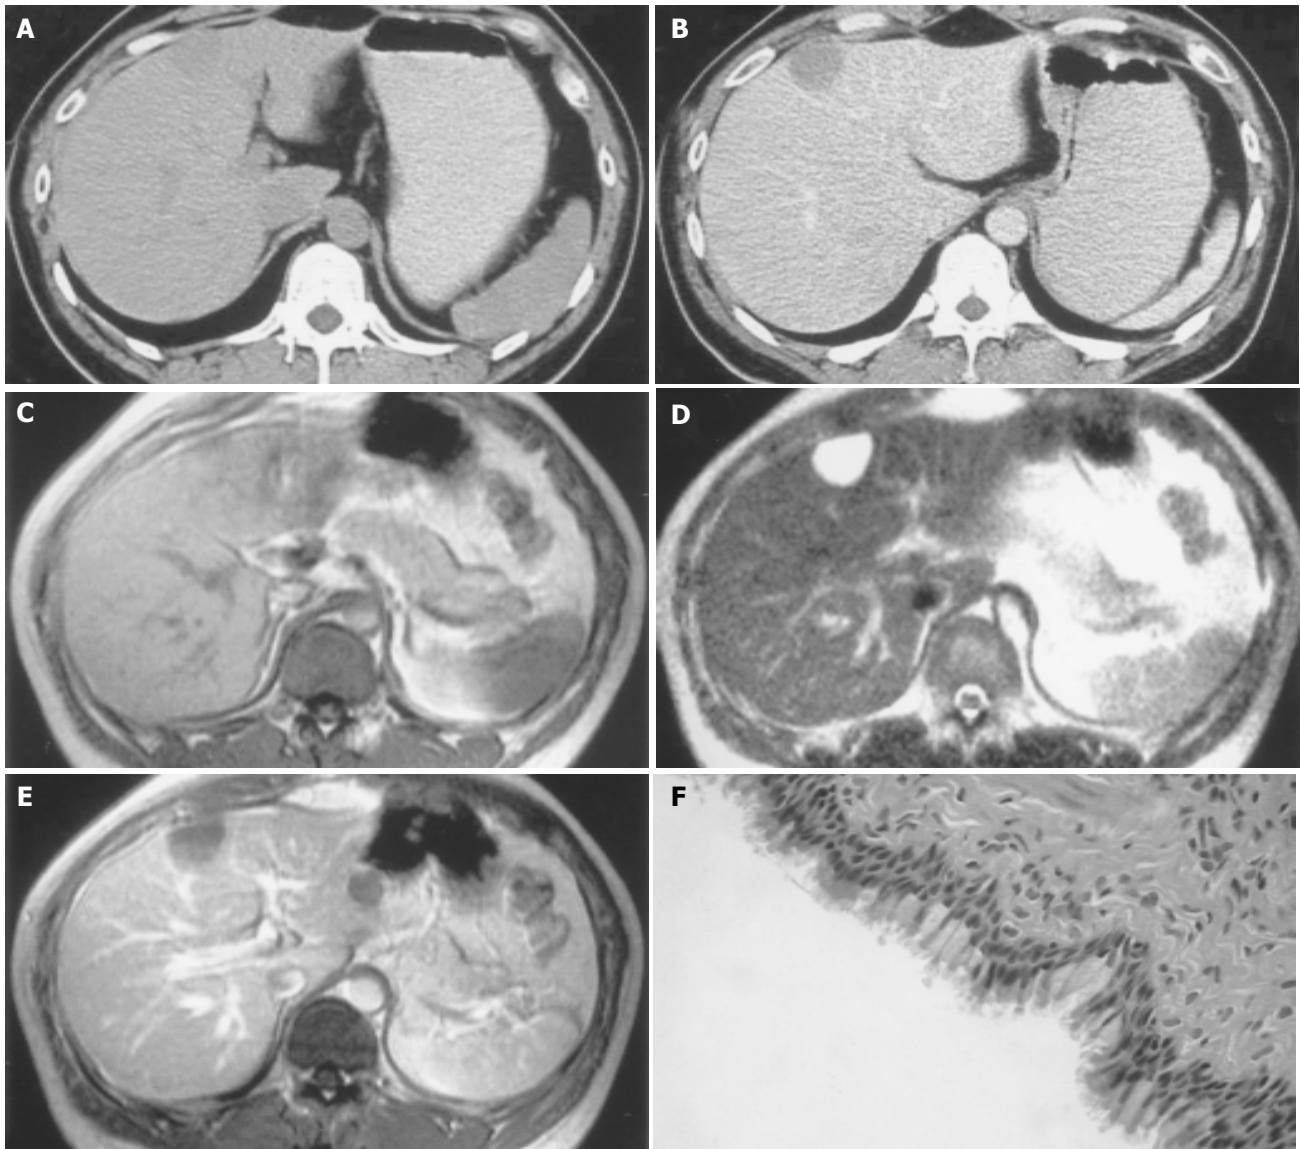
CHFC in a 30-year-old man. A: Unenhanced CT scan shows a slightly hypoattenuating (47 HU) mass in the medial segment beneath the hepatic surface; B: On enhanced CT scan, a well-defined hypoattenuating mass is revealed with no enhancement; C: On axial T1-weighted imaging, the lesion appears isointense relative to surrounding liver parenchyma; D: Axial
